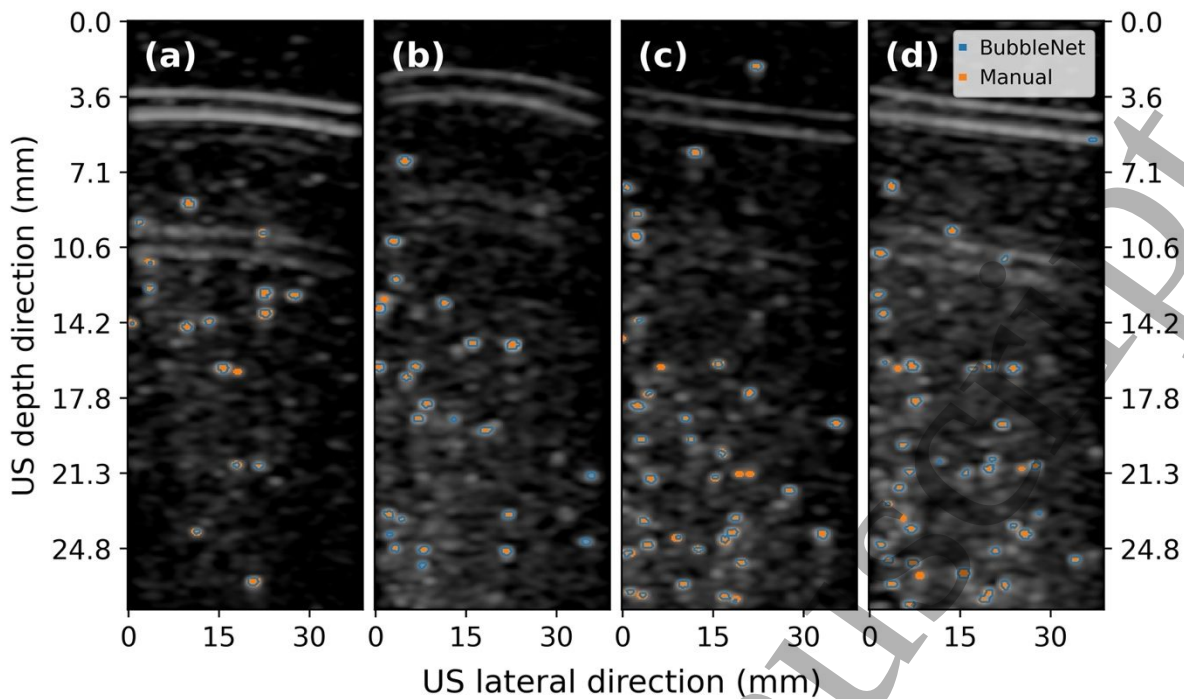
A comparison in the bubble identification performance between BubbleNet and a manual annotator on four (a-d) randomly picked differential Ultrasound frames with a high number of vaporizations per frame.
